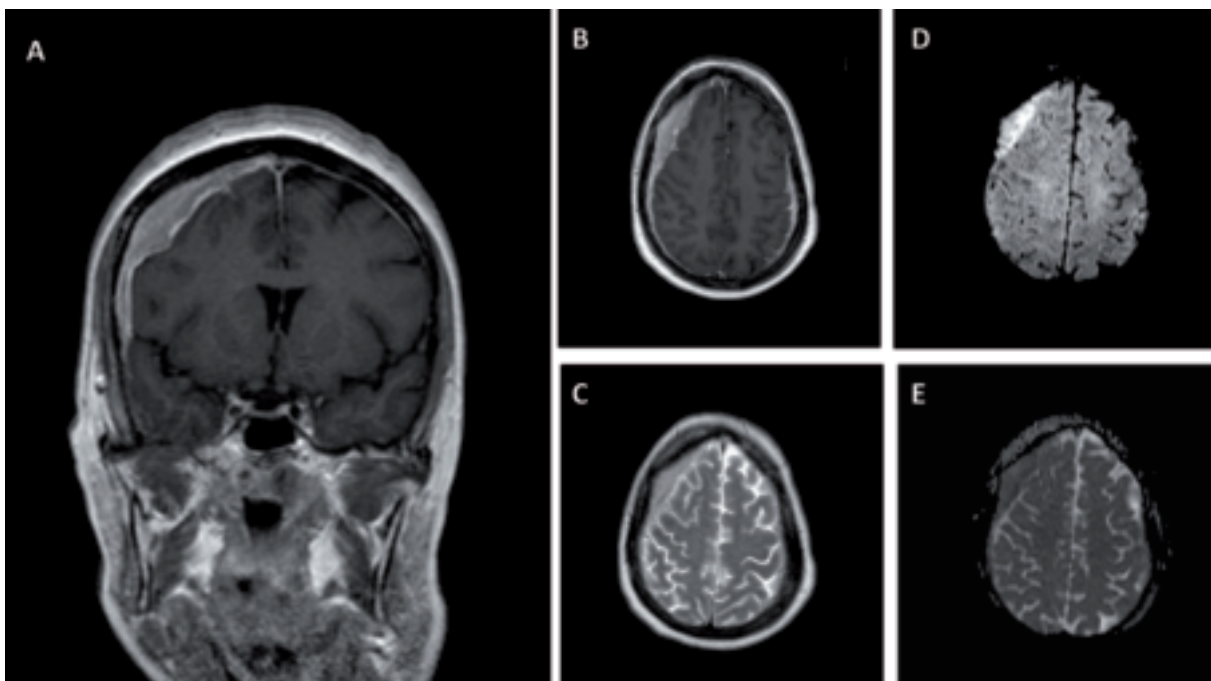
Magnetic resonance imaging showing marked and irregular thickening of the dura mater, both at the right frontal-parietal-temporal area (A) and left frontal-parietal area (B). T1 sequences with contrast: intense and homogeneous enhancement of the thickened meninges with leptomeningeal involvement (like solid tissue) (B); T2 sequences: low intensity (C); diffuse weighted imaging with high signal (D); apparent diffusion coefficient map with restricted signal (E).
